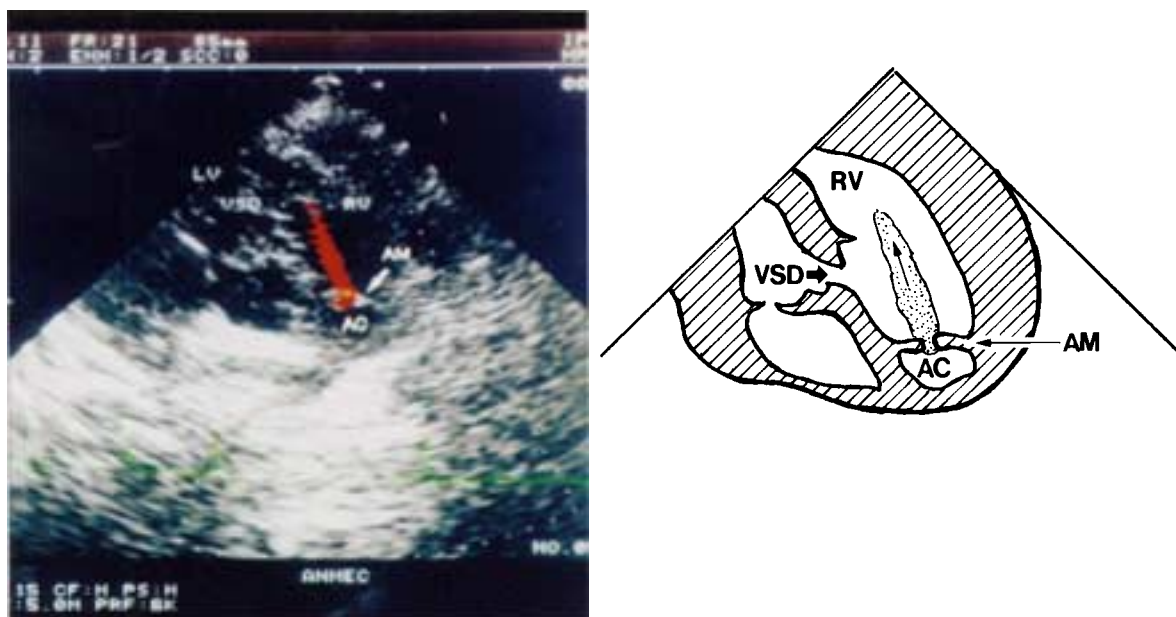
Echocardiography (regurgitation). This color-flow doppler shows regurgitation across the anomalous muscle bundle (AM). AC: accessory chamber, RV: right ventricle, LV: left ventricle, VSD: ventricular septal defect.
